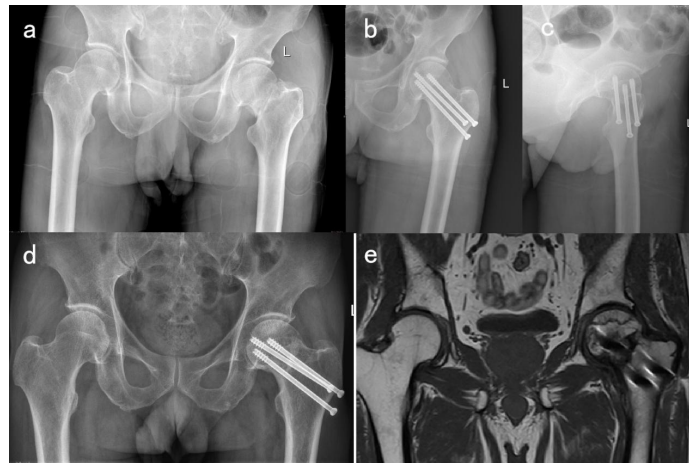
A 65-year-old male left FNF fixed with CCS. A. Preoperative X-ray showing left FNF, Pauwels III. B,C. X-ray showing excellent reduction quality at postoperative 1 week. D. X-ray showing shortening healing of the fracture and screw-out at postoperative 5 months. E. MRI showing AVN at postoperative 1.5 years.
